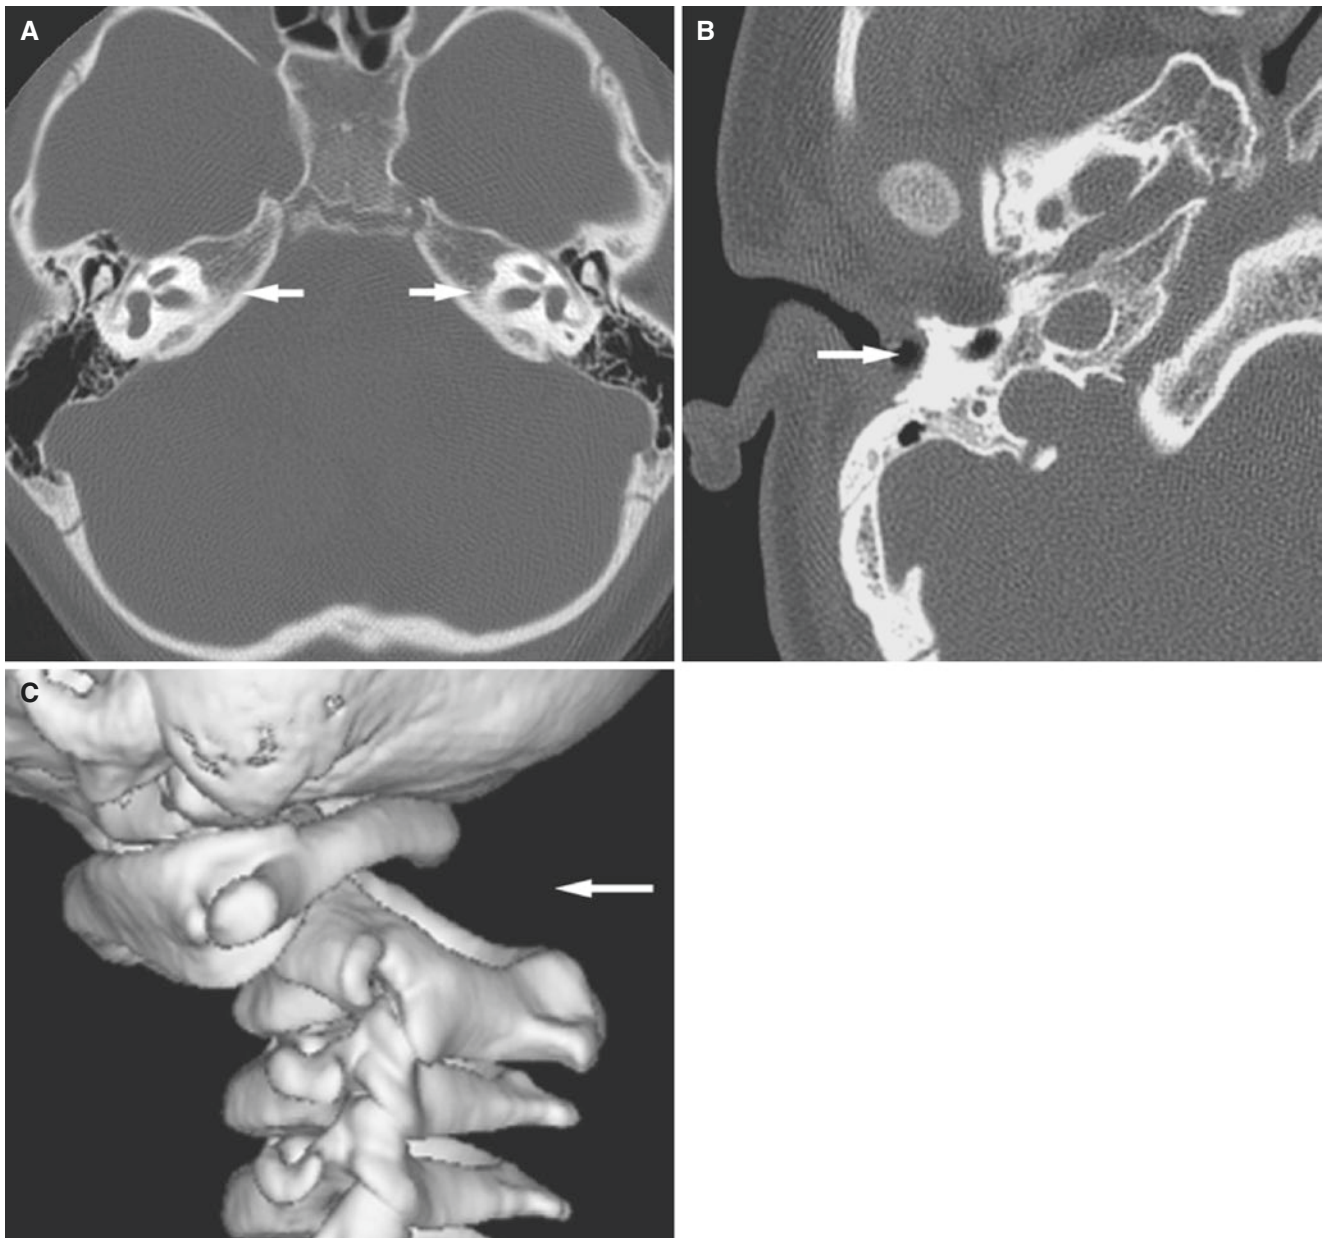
Down syndrome; 4-year-old. (A) Axial CT image shows vestibular dysplasia (*arrows*). (B) Axial CT image shows stenosis of external auditory canal (*arrow*). (C) 3D CT image shows C1–C2 dislocation (*arrow*)
